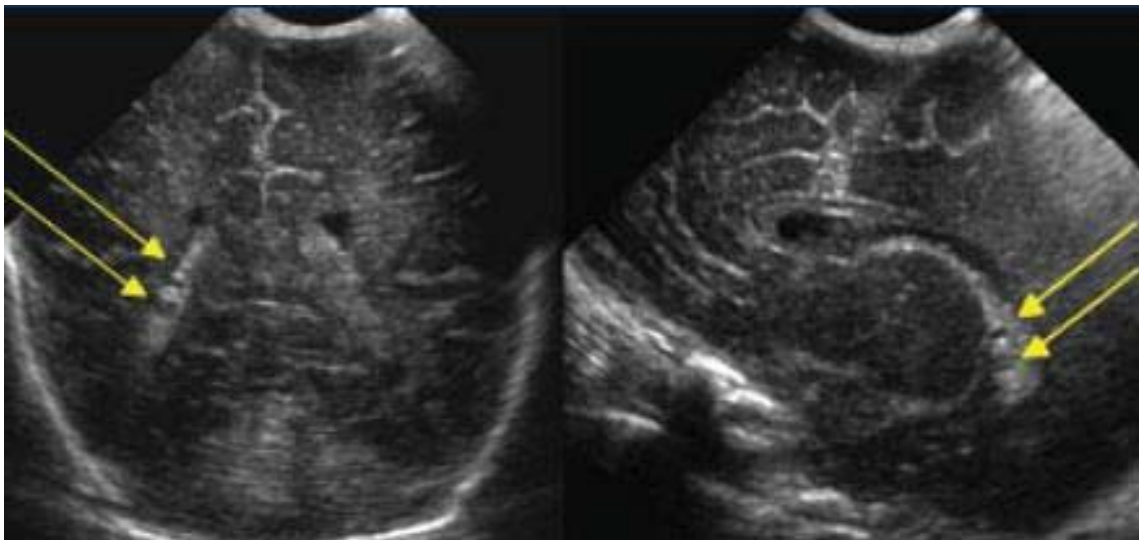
Transfontanelar ultrasound showing two left choroid plexus cysts
